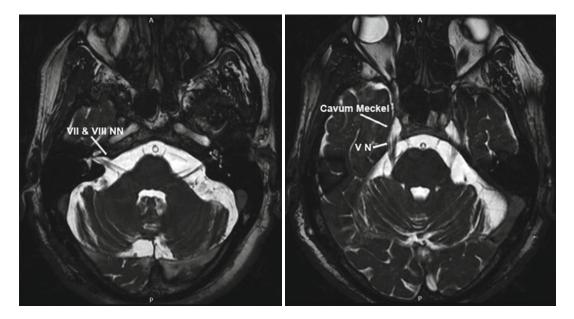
MRI CISS images depicting the seventh and eighth (*left*) and fifth and cavum Meckel (*right*)
